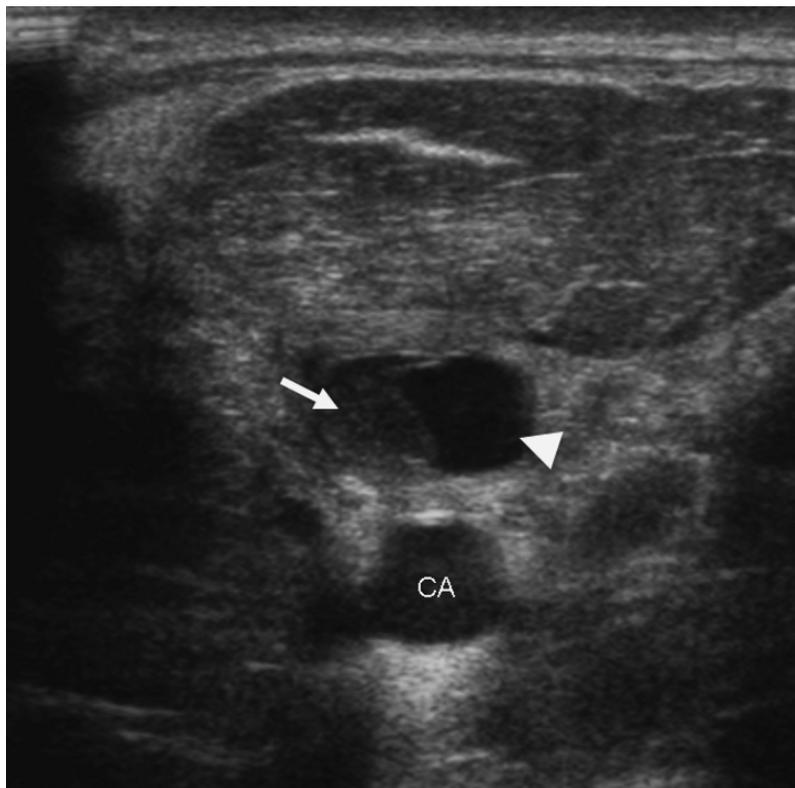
Transverse ultrasound of the IJ vein with delineation of thrombus (arrow). Arrowhead demonstrates the normal hypoechoic appearance of the patent portion of the lumen. CA: carotid artery.
